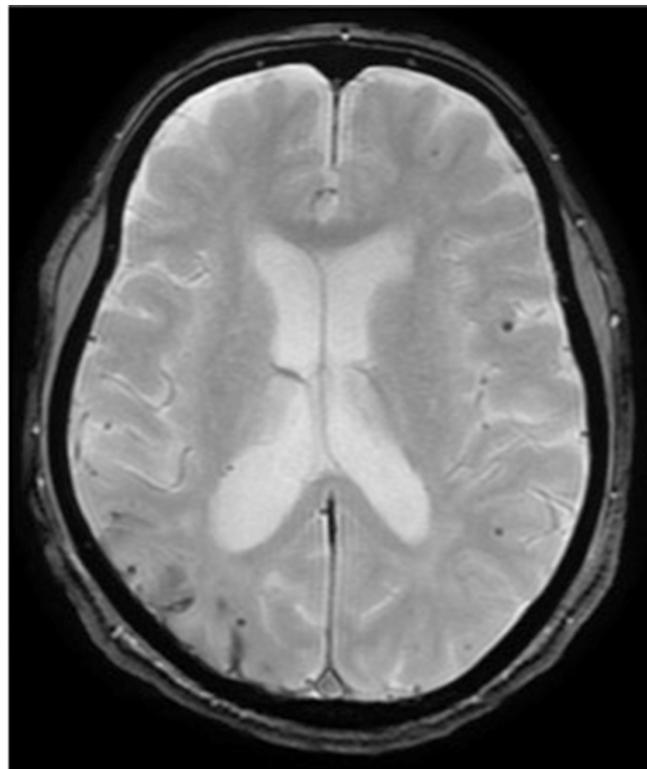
Axial T2*-weighted MRI.
